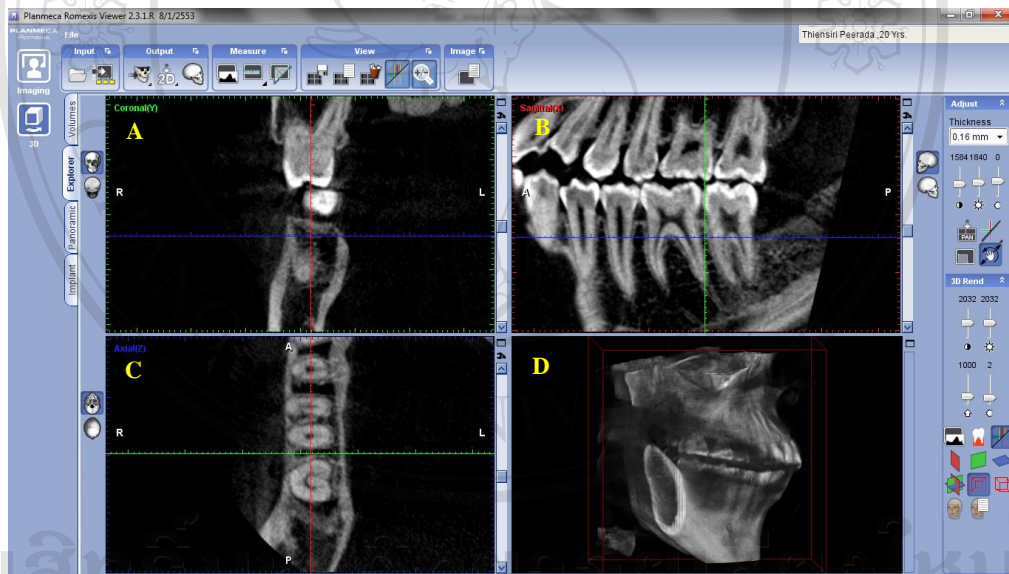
The views of the CBCT image orientation of the interradicular area between the right mandibular first and second molar, at the 4-mm height from the CEJ: A, coronal; B, sagittal; and C, axial views
